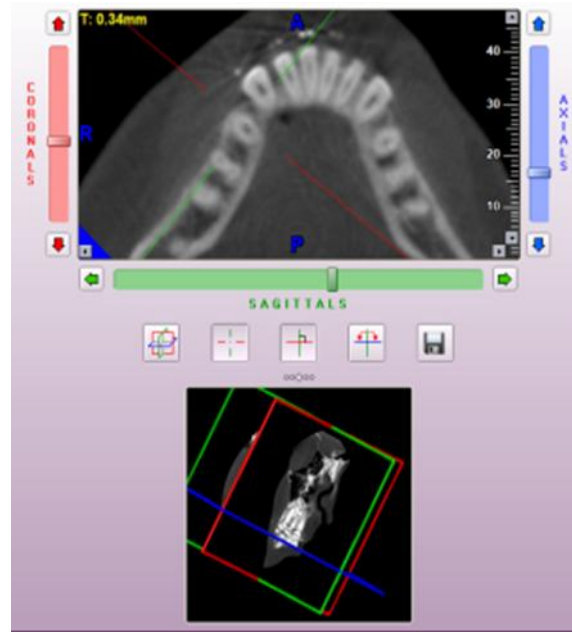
CBCT image of the premolar tooth
